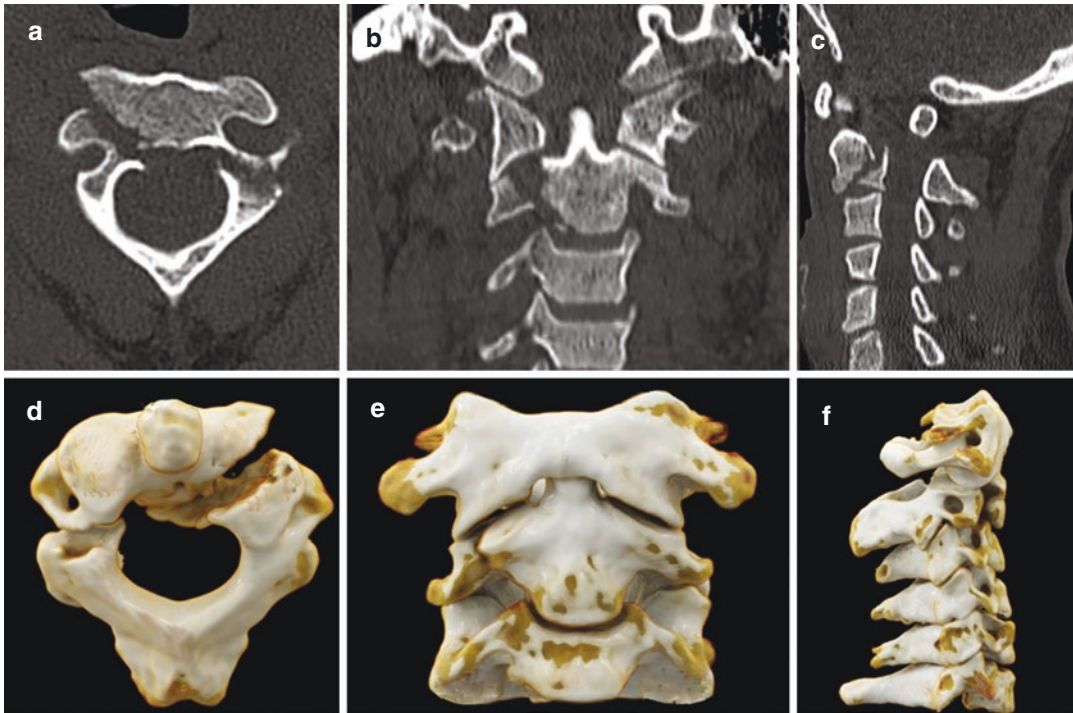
A 35-year-old male was admitted to the Emergency Department after a motor vehicle crash. Axial (a) and coronal (b) and sagittal (c) CT images and 3D reconstructions (d–f) showing detachment of bilateral
